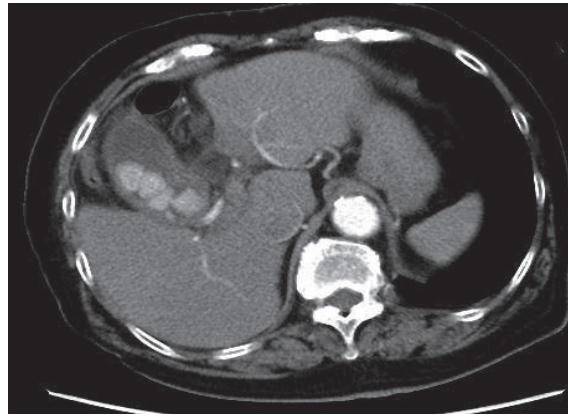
Abdominal contrast computed tomography
